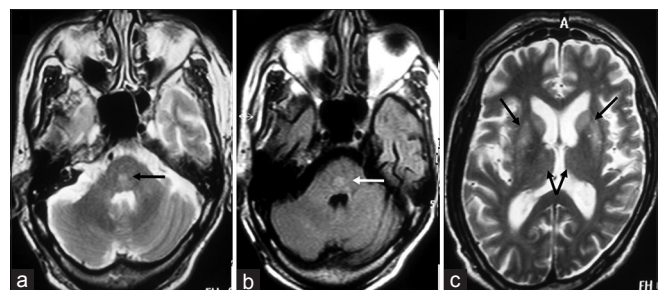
(a-c) There is central hyperintensity in the pons (arrow) on axial T2W (a) and FLAIR (fluid attenuated inversion recovery) (b) MR images of posterior fossa. Axial T2W image at the level of basal ganglia shows hyperintensity in the bilateral caudate and lentiform nuclei, as well as thalami (arrows). Imaging findings in this particular clinical scenario are diagnostic of osmotic demyelination (both central pontine and extrapontine myelinolysis)
